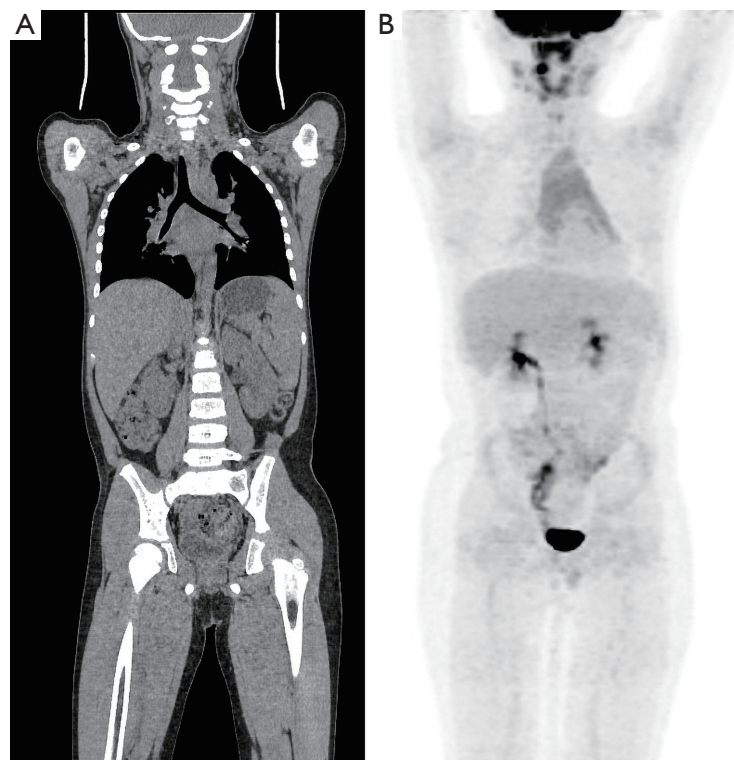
Whole-body PET/CT: (A) coronal CT image; (B) coronal PET image. CT, computed tomography; PET, positron emission tomography.
